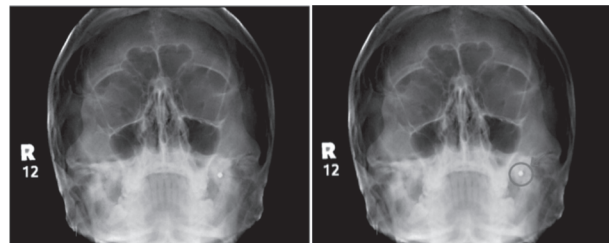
Water's View X-ray Showing the Device
